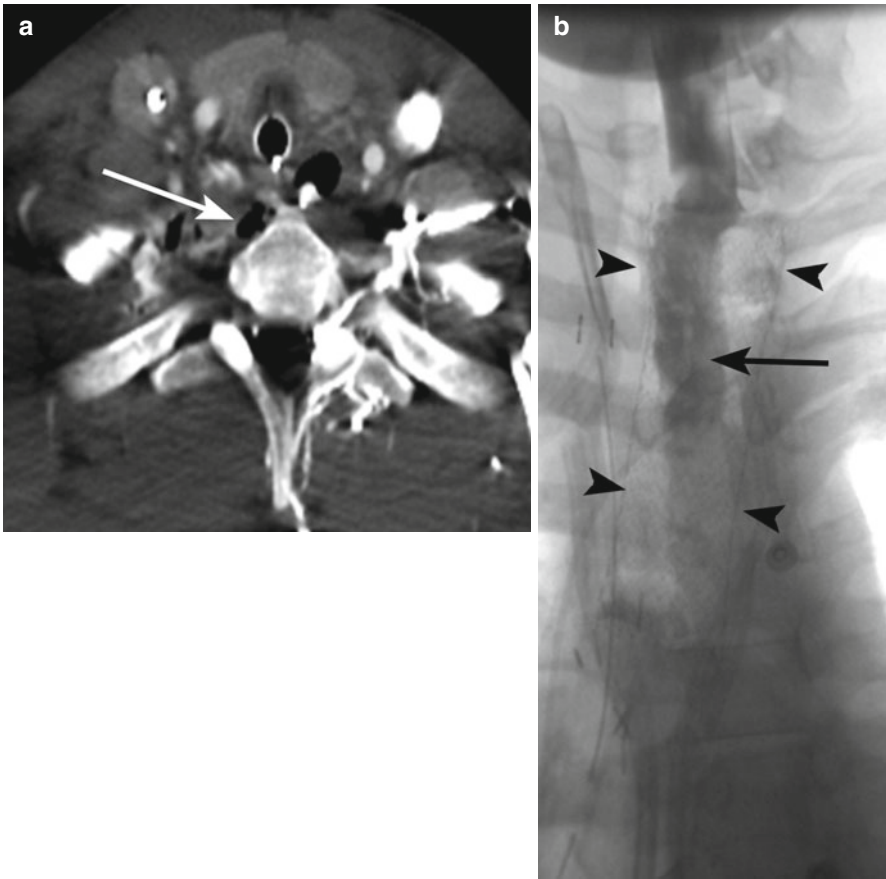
A young patient suffered a gunshot wound to the neck. (a) Initial trauma chest computed tomography (CT) demonstrated evidence of proximal posterior esophageal injury with gas and contrast (*arrow*) extending along the right apical pleural space and right neck into the supraclavicular fossa. (b) The patient was subsequently taken for emergent esophageal stenting. Post-procedure swallow study shows operative changes related to esophageal stent (*arrowheads*) placement and contrast material in the esophageal lumen (*arrow*) with no evidence of residual leak
